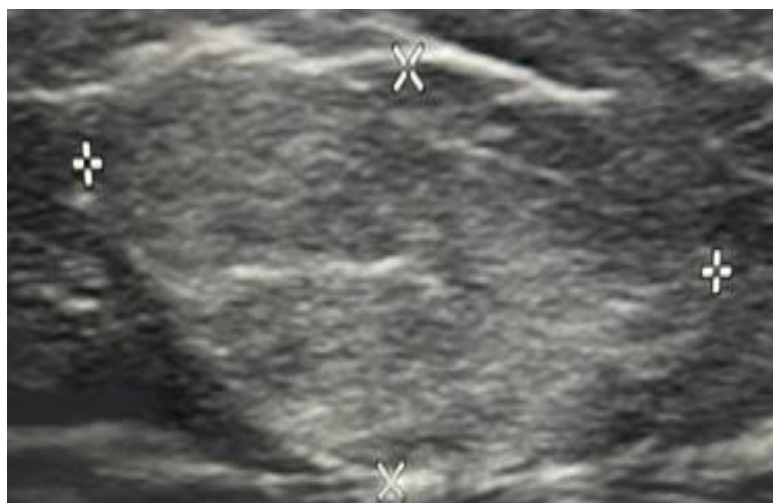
Lipoma: Ultrasound appearance
